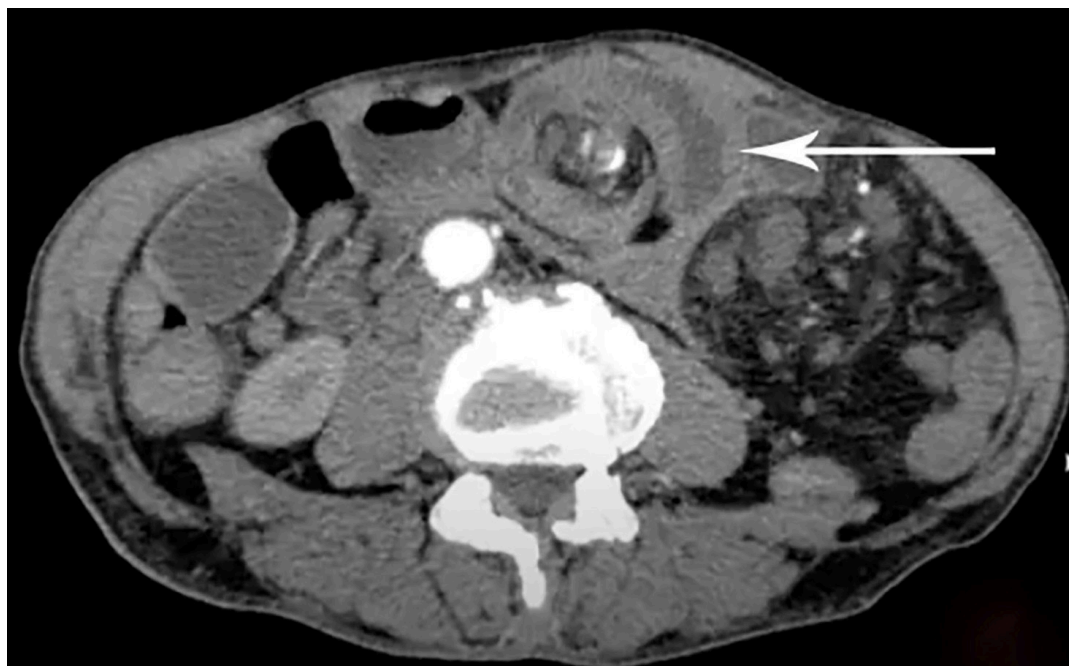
CT scan abdomen showing twisted bowel around central superior mesenteric artery
